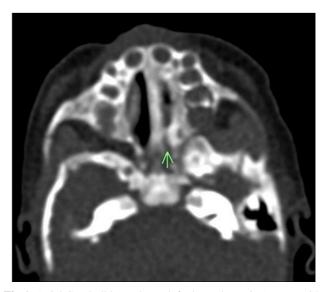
Axial CT skull base shows left choanal atresia (arrow) with retained secretions in the nasal cavity.
